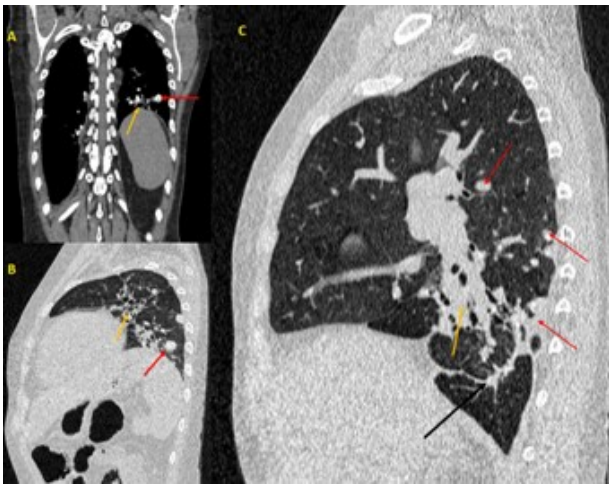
Computed tomography in the coronal (A) and sagittal (B, C) planes. The images show multiple solid nodules with well-defined margins throughout the lung parenchyma bilaterally, mainly in the lower lobes, some in subpleural location and some presenting calcifications (red arrows). It is also depicted bronchiectasis (yellow arrow) associated with subsegmental atelectasis (black arrow), in contact with a thickened pleura. These findings determine significant parenchymal distortion and volume reduction of left lung
